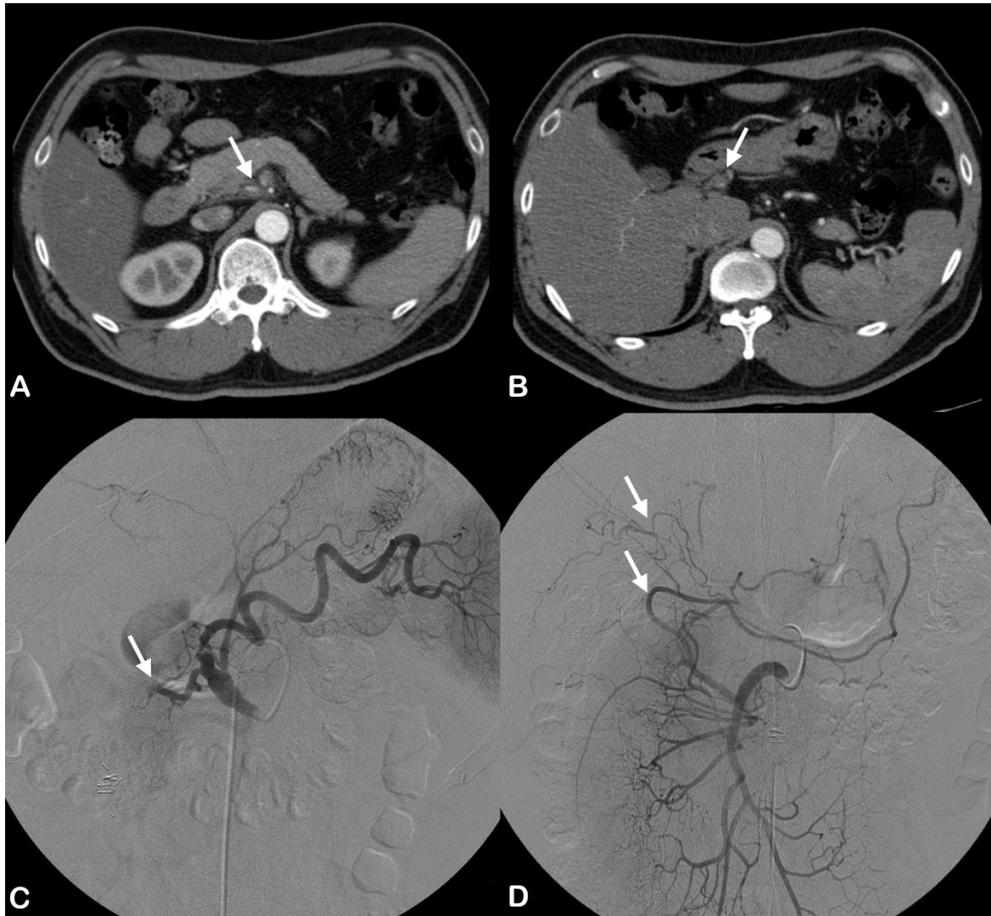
Failed delayed intervention after progression of disease. A) Initial computed tomography (CT) scans show celiac artery dissection involving the common hepatic and splenic arteries (arrow). B) Follow-up CT scans after 6 days reveal more sluggish flow to the proper hepatic artery (arrow) with persisting abdominal pain. C) Near total occlusion of the hepatic artery (arrow). D) Insertion of the stent will block collaterals from the superior mesenteric artery (arrows).
